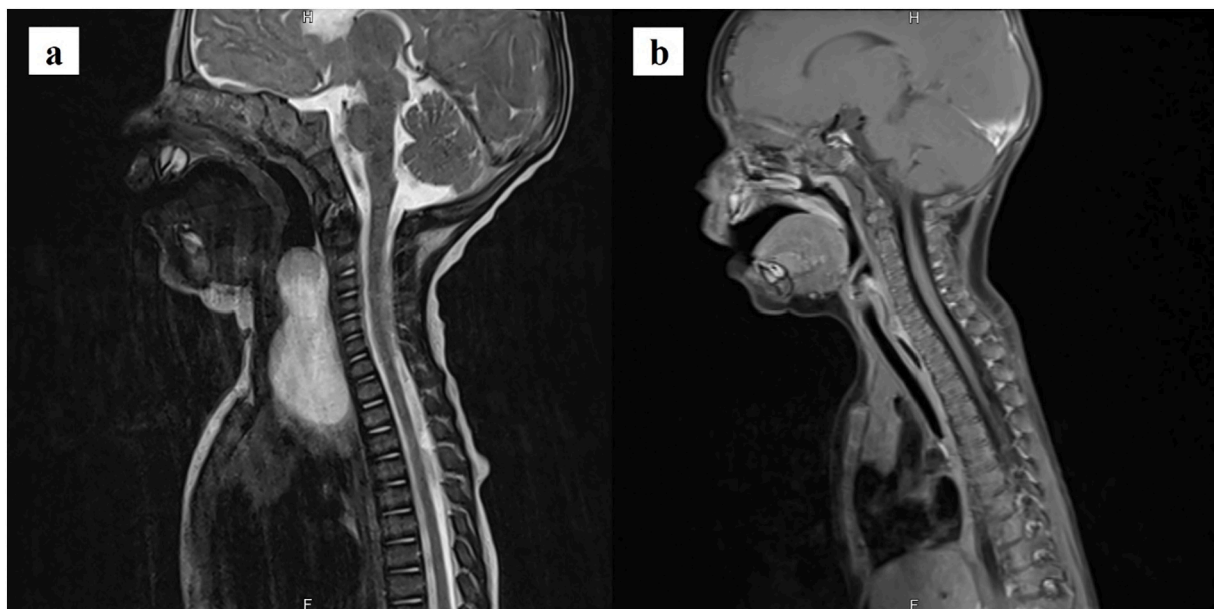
MRI imaging of the neck. (a) Retrotracheal cystic mass between the esophagus and trachea. The upper pole protruded into the hypopharynx and was portrayed during pharyngoscopy (Fig. 2). The lower pole had contact with the upper mediastinum and was exposed during surgery (Fig. 3-a). (b) Follow-up MRI 3 months after the surgery.
